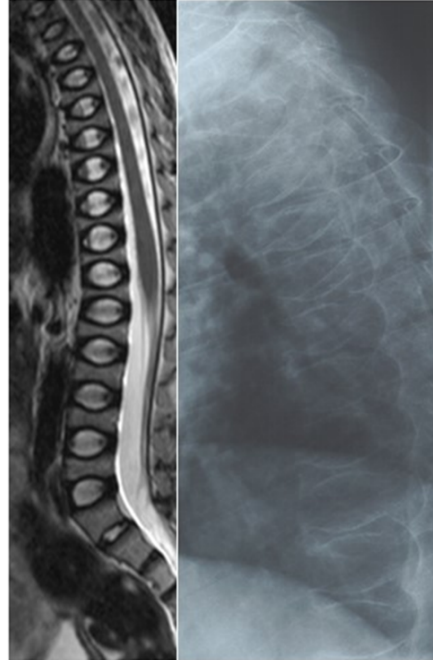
C. Multiple vertebral fractures in the thoracic and lumbar spine of a 9-year-old girl with systemic JIA. In Th11-L4 intervertebral disc spaces, a slight increase in height of the discs with normal signal intensity (bright) and in the presacral disc a protrusion (arrowhead) and decreased signal intensity (dark, thin arrow) are seen. Lumbar radiograph also shows wedge deformities (L1 2b, L2 2a, arrow) and compression deformities (L3-5 3a, open arrow). Sclerotic vertebral margins are due to bisphosphonates. D. All subcervical vertebrae except L5 in a 14-year-old girl with treatment-resistant psoriatic arthritis are severely compressed (Grade 3b), and all intervertebral discs are markedly ballooned. Compressions in the thoracic spine are visible also in radiography, although bone seems severely osteoporotic.
